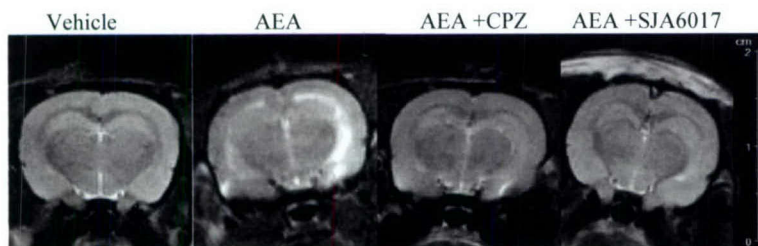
Representative T2-weighted images obtained 24 h after right icv injection of vehicle, AEA (20 nM), AEA with VR1 receptor antagonist CPZ (35 nM), or AEA with calpain VI inhibitor SJA6017 (1 μg). Increased signal intensity (white arrows) shows regions with increased ADC (hippocampus, dentate gyrus, cerebral ventricle) suggesting presence of edema.
